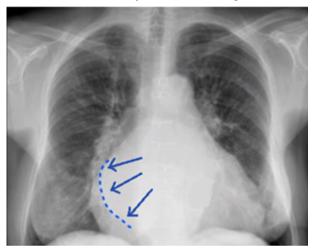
Chest X-ray of the thorax. PA view. Double density sign in a patient with enlarged left atrium due to significant mitral regurgitation.
